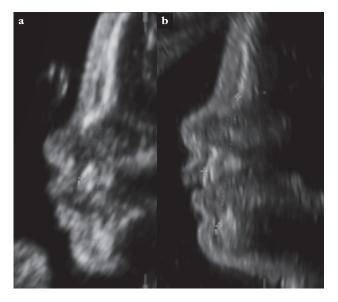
Ultrasound pictures of cases with CL. Case 1 (A) with smallest (12.5°) and case 9 (B) with largest (16.9°) MNM angle in CL group.
